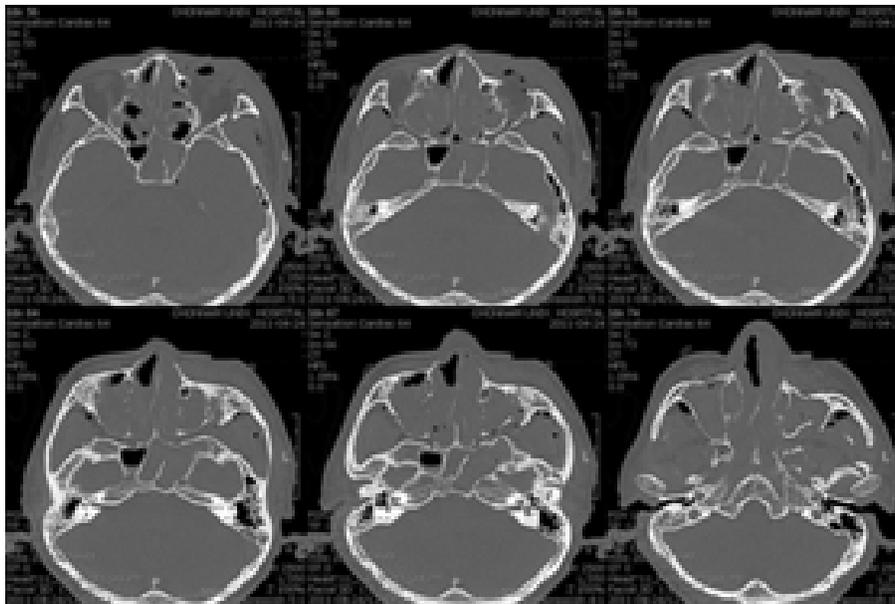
The CT examination revealed Le Fort II, NOE, left zygomaticomaxillary complex fracture, maxillary palatal fracture and right mandibular parasymphysis fracture.
